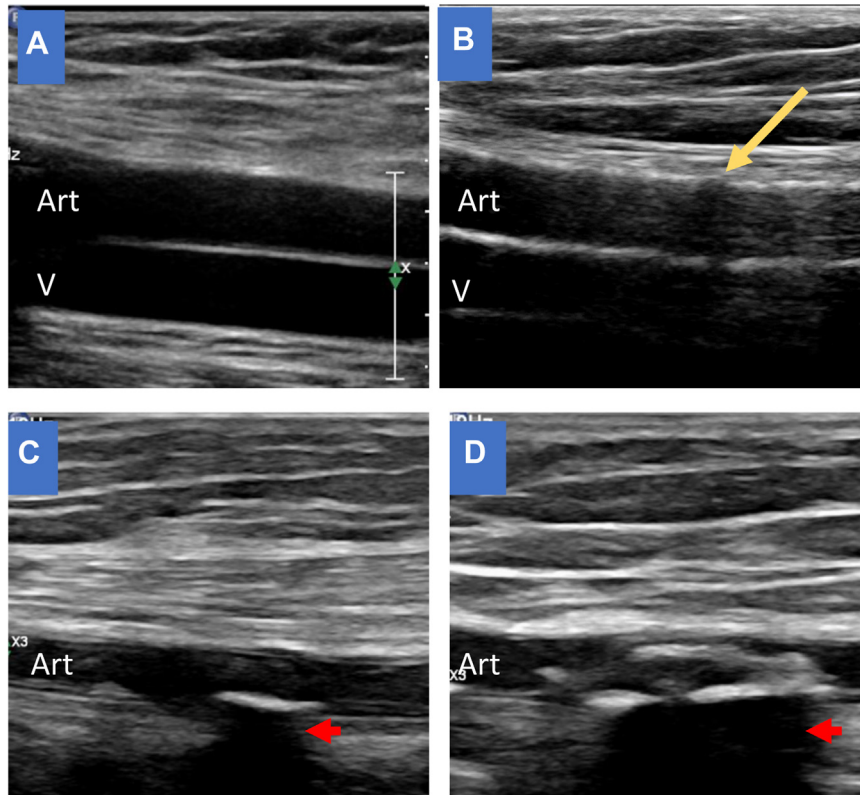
Ultrasound (US) images and scoring system for arterial calcification. A, Score of 0: US scan showing no echogenic shadowing or intimal irregularity. B, Score of 1: US scan showing discontinuous hyperechoic wall irregularities (*yellow arrow*). C,D, Score of 2: US images showing distinct anechoic shadowing (*red arrows*). Art, Artery; V, vein.
